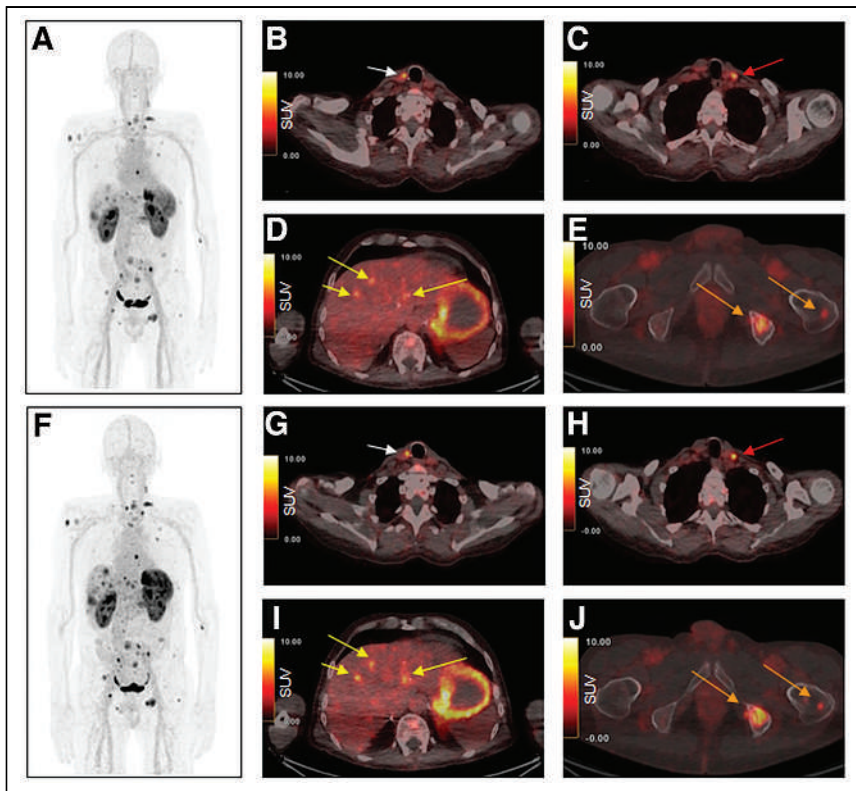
Maximum-intensity projection and axial PET/CT images 1 h (A–E) and 2 h (F–J) after injection of ^{68}Ga -DOTA-MGS5 into metastatic MTC patient (calcitonin, >2,000 ng/L). Images show local recurrence in right paratracheal region, with SUV_{max} of 7.8 and 8.5 at 1 and 2 h, respectively (B and G; arrows). A cervical lymph node metastasis is seen in left cervical region, with SUV_{max} of 7.1 and 8.1, respectively (C and H; arrows). Three liver metastases are seen, with SUV_{max} of 5.5, 6.3, and 5.3 vs. 6.7, 7.1, and 6.7, respectively (D and I; arrows). Bone metastases are also seen, in left iliac bone (SUV_{max} of 7.6 and 9.7, respectively) and left femur (SUV_{max} of 3.6 and 5.1, respectively) (E and J; arrows).
